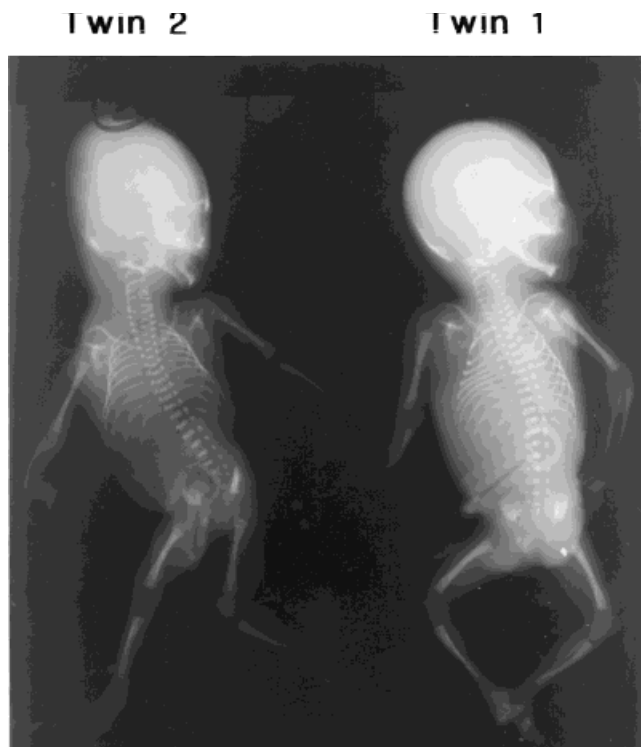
Fetal postmortem roentgenograph. The right radius of twin 1 is hypoplastic and the radial ray is absent. The right radius of twin 2 is absent and the radial ray is absent in both hands.
